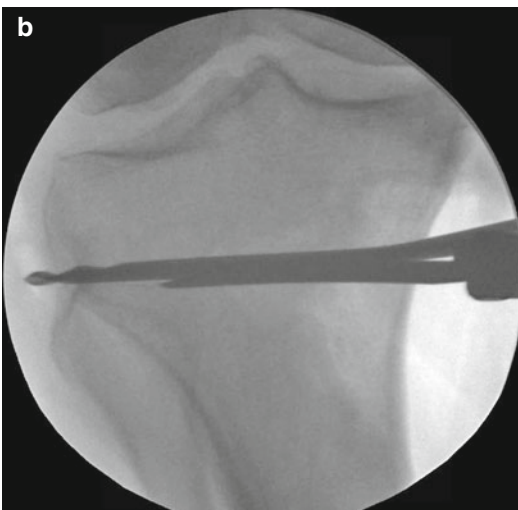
8 Intraoperative fluoroscopy. The leg can be brought laterally and onto a mini C-arm for radiographic localization
